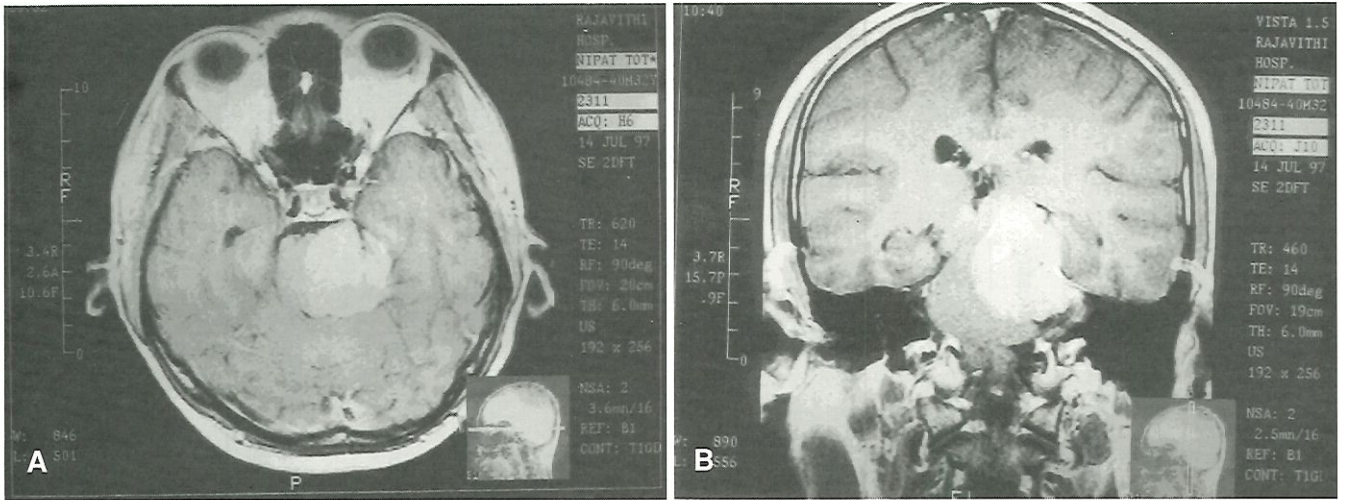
MRI of the patient Case 5 showing the petroclival meningioma.
